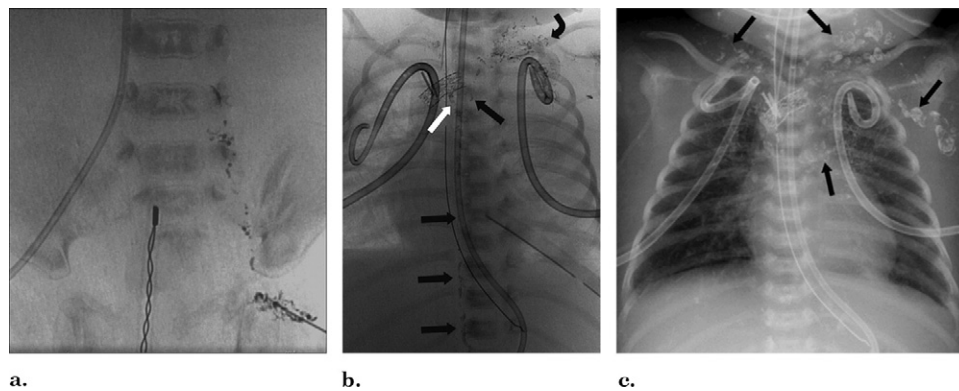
Patient 1. (a) Spot radiograph of the left groin shows the initial phase of intranodal injection with opacification of a left inguinal lymph node and pelvic lymphatic channels. (b) Spot radiographs (obtained 70 min after starting injection) shows diverted flow from the thoracic duct into the lymphatics of the neck and axilla (bent arrow) denoting obstruction of the terminal portion of the thoracic duct. Note opacification of normal cisterna chyli and left thoracic duct (black arrows) as well as the right thoracic duct (white arrow). There is a metallic stent in the left innominate vein (overlapping with surgical clips) and bilateral chest, endotracheal, and nasogastric tubes. (c) Chest radiograph 25 days after the procedure shows retained ethiodized oil in the lymph nodes of the neck, chest wall, axilla, and mediastinum (arrows).
